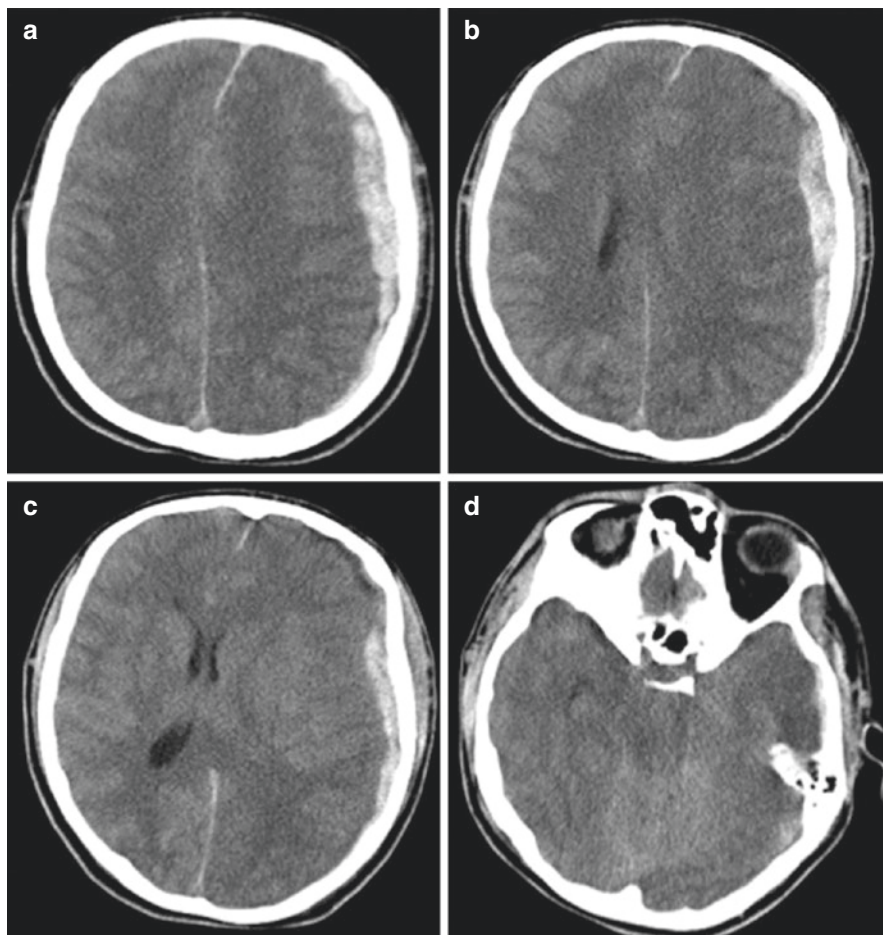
Non-contrast CT of head for SDH SRSBI with DCE. (a) 12-mm acute left convexity subdural hemorrhage with effacement of bilateral sulci and clear midline shift; (b) acute hemorrhage again demonstrated with near total effacement of left lateral ventricle; (c) midline shift measured at 10-mm; (d) complete effacement of basal cisterns with uncal herniation. (With permissions from Yengo-Kahn et al. [49])
